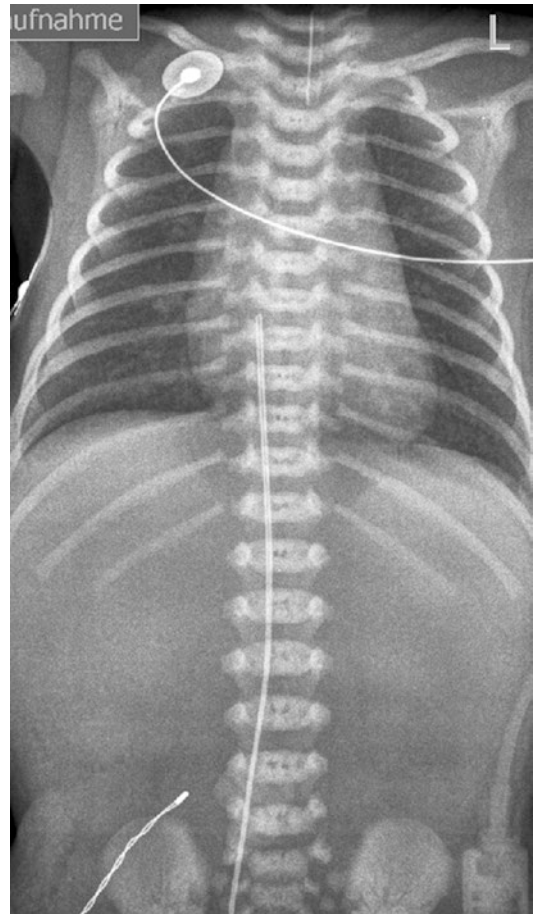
X-ray of a newborn baby with a pure EA (type A). The tip of the Replogle tube marks the lowest point of the upper pouch at approximately the level of the clavicles. No gas is passing into the gastrointestinal tract
